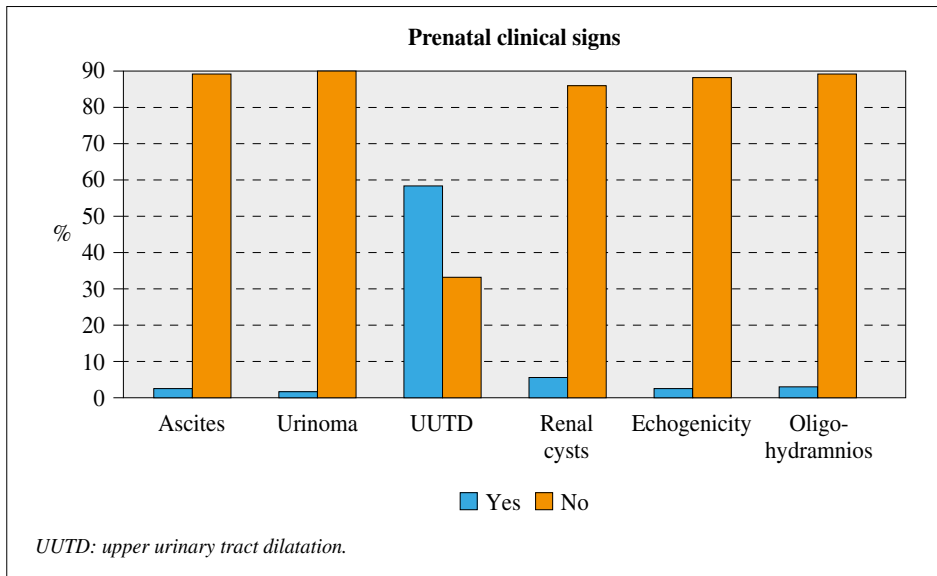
Prevalence of prenatal ultrasonography abnormalities in PUV patients.
